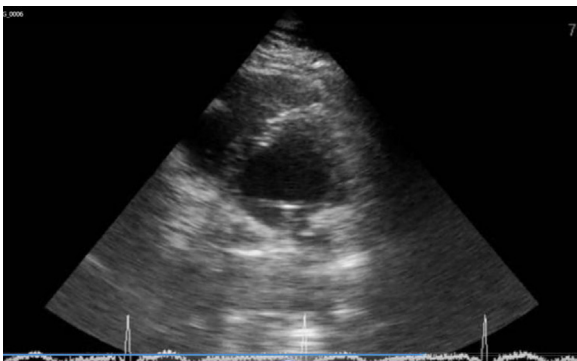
A patient with obstructive mitral PVT. TTE of parasternal short axis view showed medial leaflet of mitral bileaflet valve was stuck in closed position and lateral leaflet was moved to open position during diastole.
